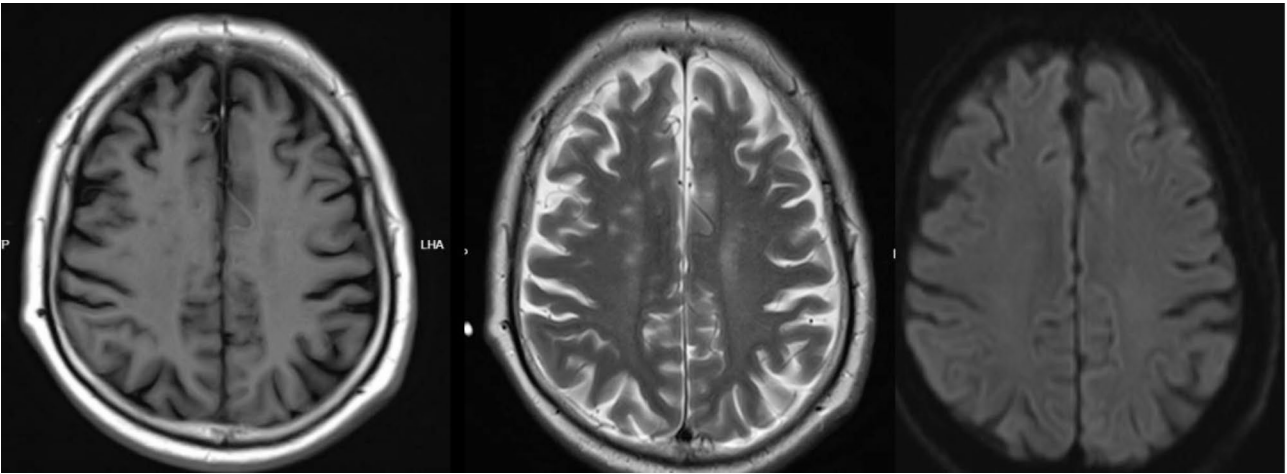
Multiple ischemic foci with T2 Flair and no abnormalities on T1 and DWI. MR of the head showed multiple ischemic lesions in the brain, and no obvious abnormal signs
